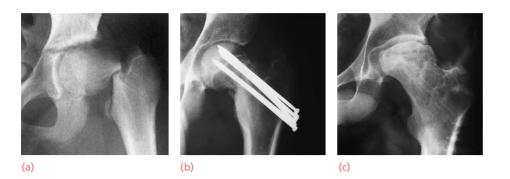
Avascular necrosis (a) Displaced fractures of the femoral neck are at considerable risk of developing avascular necrosis. Despite internal fixation within a few hours of the injury (b), the head-fragment developed avascular necrosis. (c) X-ray after removal of the fixation screws.
